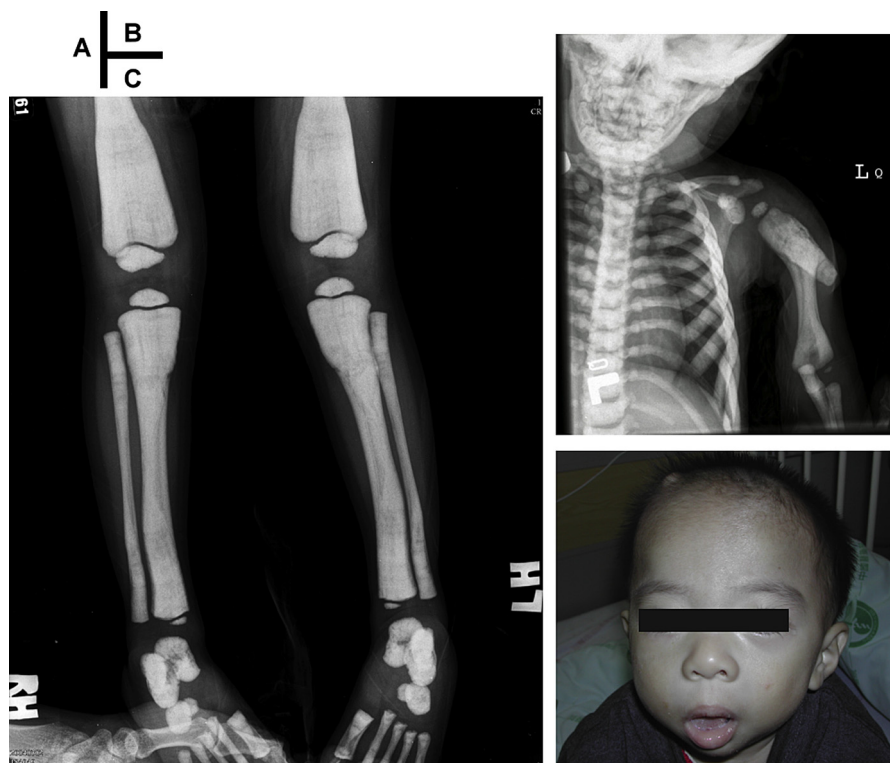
Images of the patient at 2-years-9-months of age. (A) Loss of the bone marrow cavity in the long bones as shown in plain film. (B) Radiographic evidence of a left humerus fracture. (C) Asymmetrical facial expression owing to right facial nerve palsy and a bulging mass over the right parietal area of the scalp disclosing the insertion site of the ventriculoperitoneal shunt.
